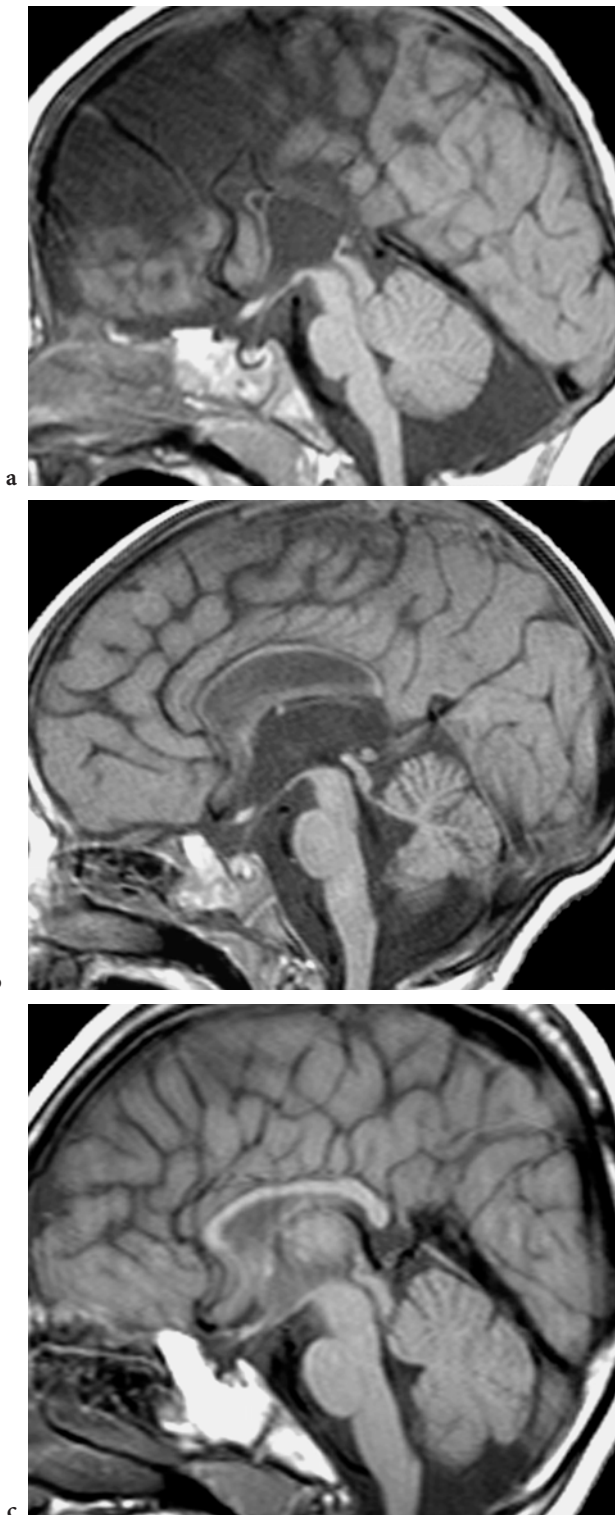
Callosal abnormalities in nonketotic hyperglycinemia on sagittal T1-weighted spin-echo images. a Callosal agenesis in a 6-month-old male patient. b Callosal hypoplasia in a 9-month-old female patient. c Callosal hypotrophy in a 4-month-old male patient
